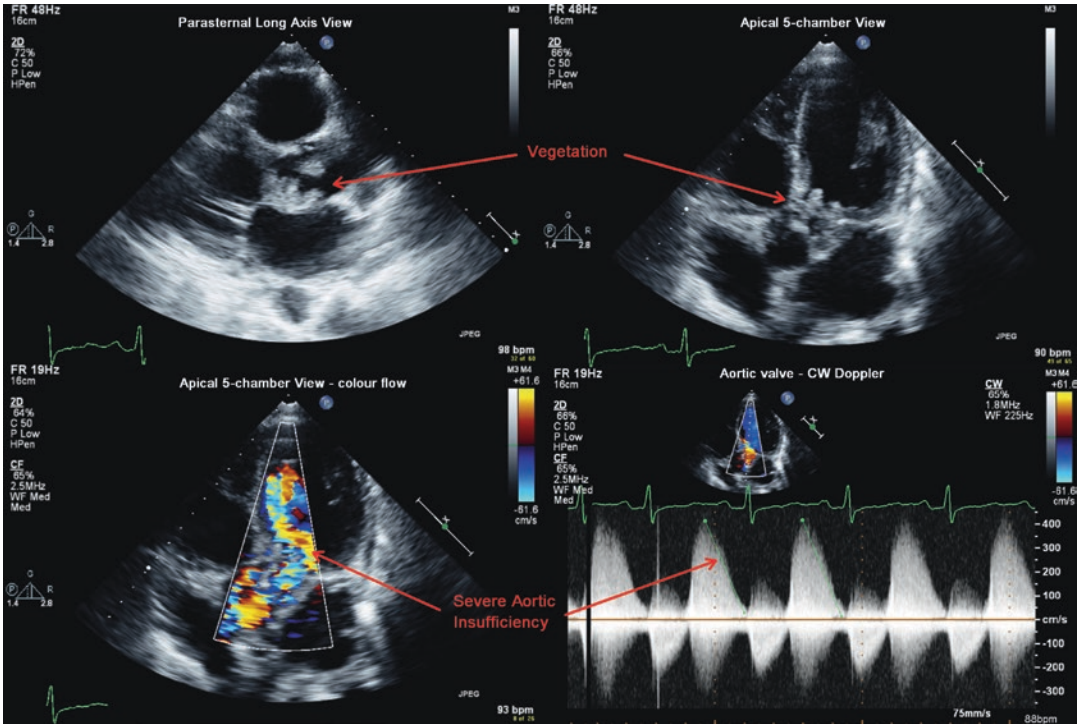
Transthoracic echocardiogram documenting an aortic valve vegetation and severe aortic insufficiency in the parasternal long axis view and the 5-chamber apical
